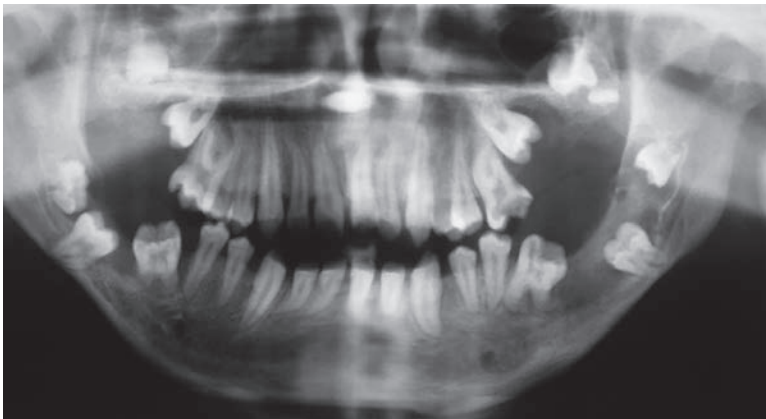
Panoramic radiograph taken 18 months postoperatively showing significant bone formation in the region of the cystic lesions.
